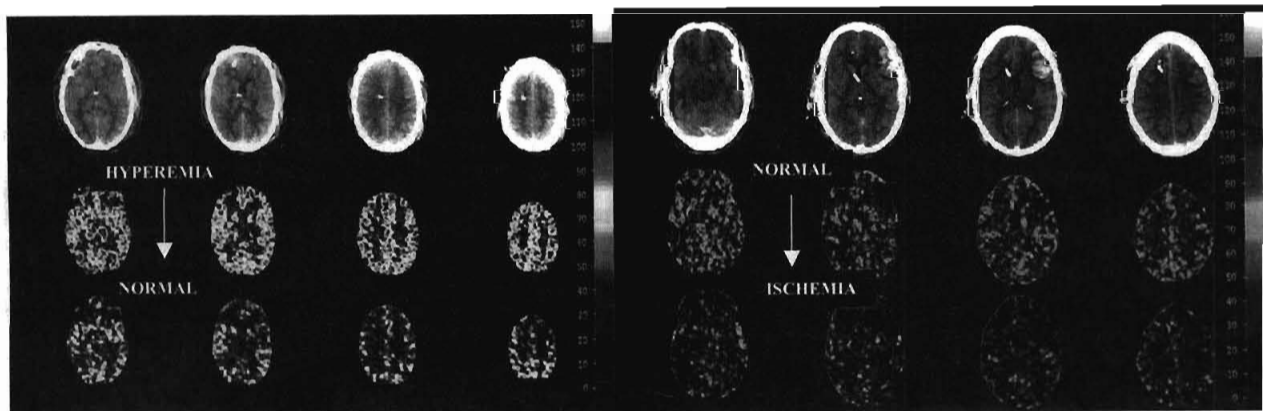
Effects of PaCO_2 changes on cerebral blood flow (CBF). Two examples of disparate effects of hyperventilation on CBF. Both figures are stable xenon CBF scans in head trauma patients with and without hyperventilation. CBF scale is indicated on the right in mL/100 g/min and Pco_2 is indicated above each study. Computed tomography images are indicated in the upper figures and CBF maps in the lower figures. In the left figure, PaCO_2 was decreased from 40 to 30 mm Hg. The baseline scan shows hyperemia and the hyperventilated scan shows CBFs of approximately 60 to 70 mL/100 g/min, probably acceptable flows. In the right figure, PaCO_2 was decreased from 38 to 30 mm Hg. The baseline CBFs were acceptable. The effect of this modest extent of hyperventilation was to produce widespread areas of CBF less than 20 mL/100 g/min, probably unacceptable flows. (See color section in this text.) (Courtesy of Howard Yonas, University of Pittsburgh.)
